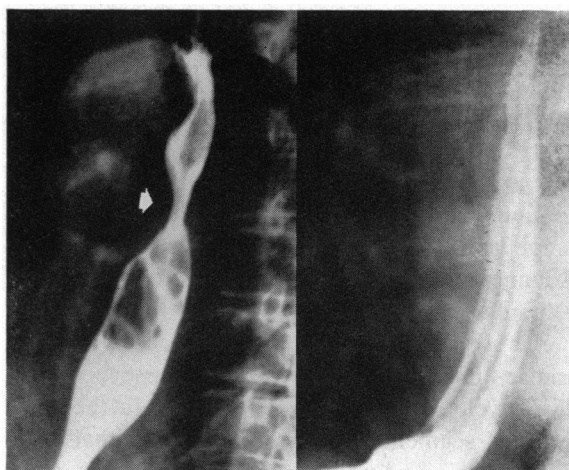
Lower esophagus abnormally lined by columnar epithelium with esophageal stricture due to tryptic esophagitis. Total gastrectomy and esophago-jejunosotomy seven years previously for gastric carcinoma. Severe symptoms of gastroesophageal reflux since operation. Recent onset of dysphagia. *Left*, esophagram demonstrates esophageal stricture (arrow) just distal to aortic arch. Esophagoscopy and biopsy revealed that the esophagus below the stricture was lined by columnar epithelium with a few abnormal villi, resembling jejunal mucosa. *Right*, mucosal pattern of lower esophagus (distal to the stricture) appears normal roentgenographically. (Through courtesy of Dr. F. Dick Berridge, Director, Diagnostic Radiologic Departments, The United Cambridge Hospitals, England.)
